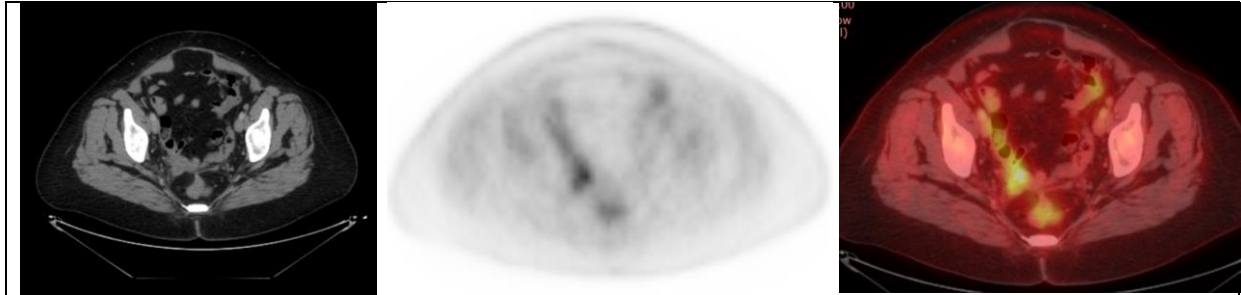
CT, PET & PET/CT images: Right operative bed mass lesion FDG avid uptake with SUV max 3.6.
